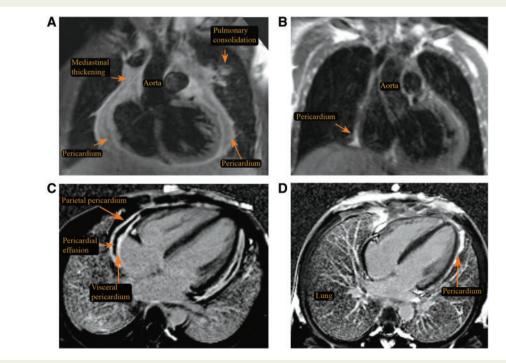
Cardiac magnetic resonance imaging before and after treatment. (A) Cardiac magnetic resonance imaging showing thickened pericardium in continuum with mediastinal thickening. (B) Cardiac magnetic resonance imaging after treatment, at Day 167 post-discharge, depicting resolution of pericardial thickening. (C) Late gadolinium hyperenhancement showing thickening of all layers of pericardium with small pericardial effusion. (D) Cardiac magnetic resonance imaging after treatment, at Day 167 post-discharge.
